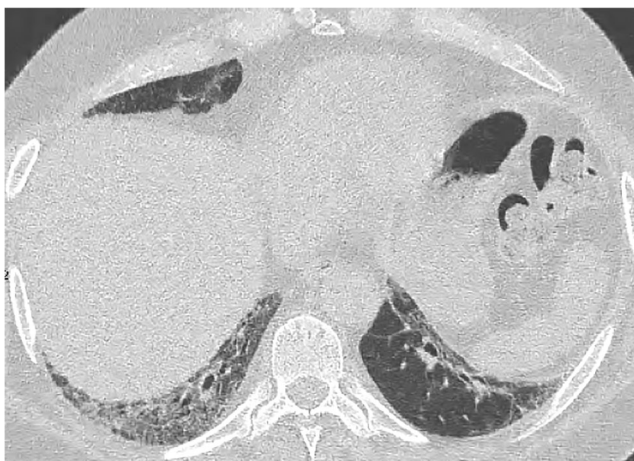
HRCT of a 67-year-old woman with lower lobe-predominant ground-glass opacity, reticular abnormality, and traction bronchiectasis is compatible with NSIP pattern. The patient initially presented with muscle weakness, which was suspicious for an inflammatory myopathy but had negative serology. Five years after her initial CT, she developed anti-Jo antibodies and was diagnosed with antisynthetase syndrome. HRCT high-resolution computed tomography, NSIP nonspecific interstitial pneumonia
